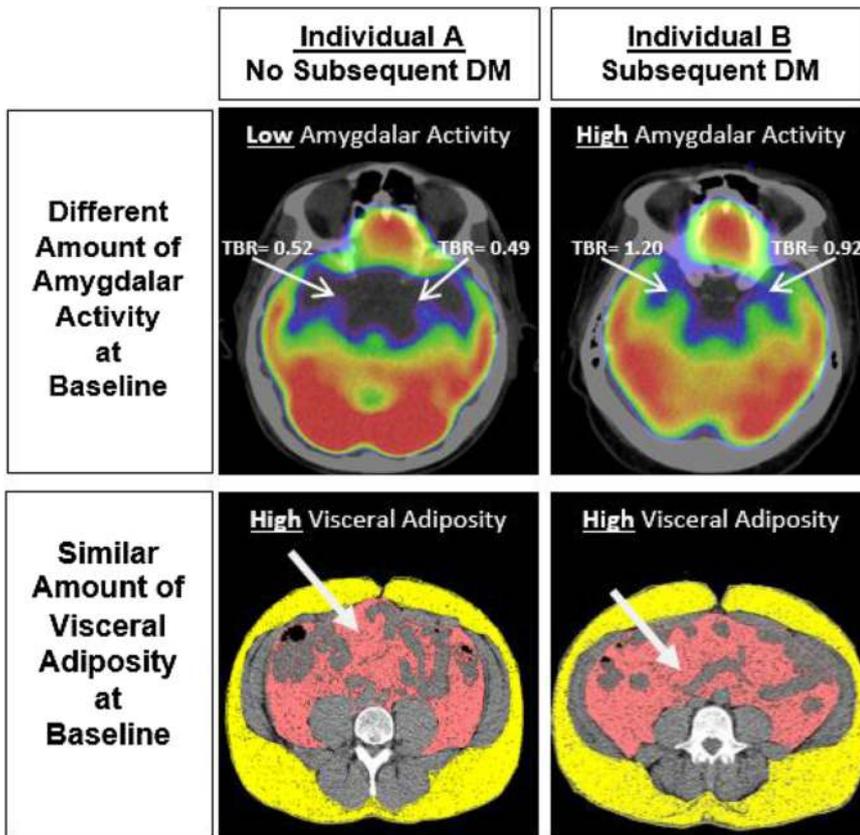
Imaging of amygdalar activity and adiposity in individuals with vs. without subsequent type 2 diabetes. Axial views of amygdala (upper right and left ^{18}F -FDG-PET/CT images) and adipose tissues are shown (lower right and left CT images) from two individuals. Both individuals were obese and had similar amounts of visceral adipose tissue. However, AmygA was increased in the individual who developed DM (right) compared to the individual who did not (left).
